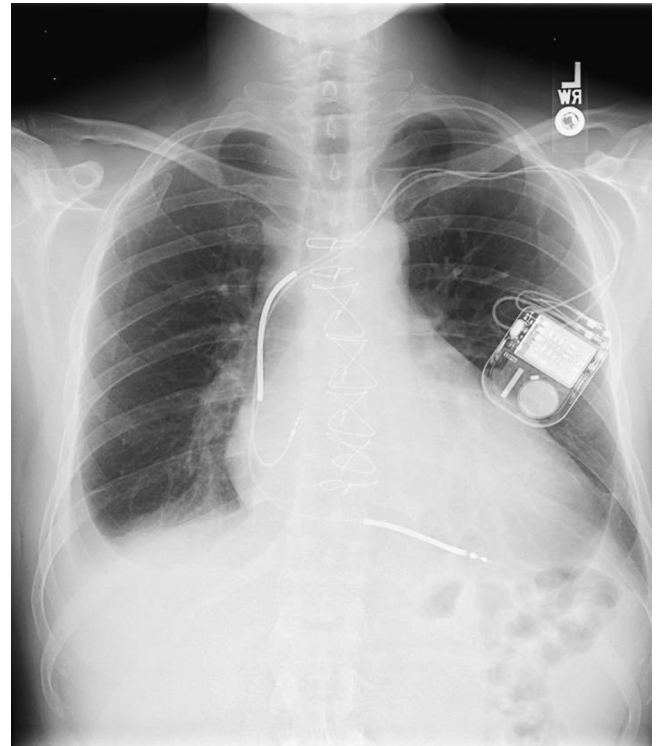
■ Chest x-ray appearance of ICD. Note the thick radiopaque sections on the right ventricular lead of ICD.
